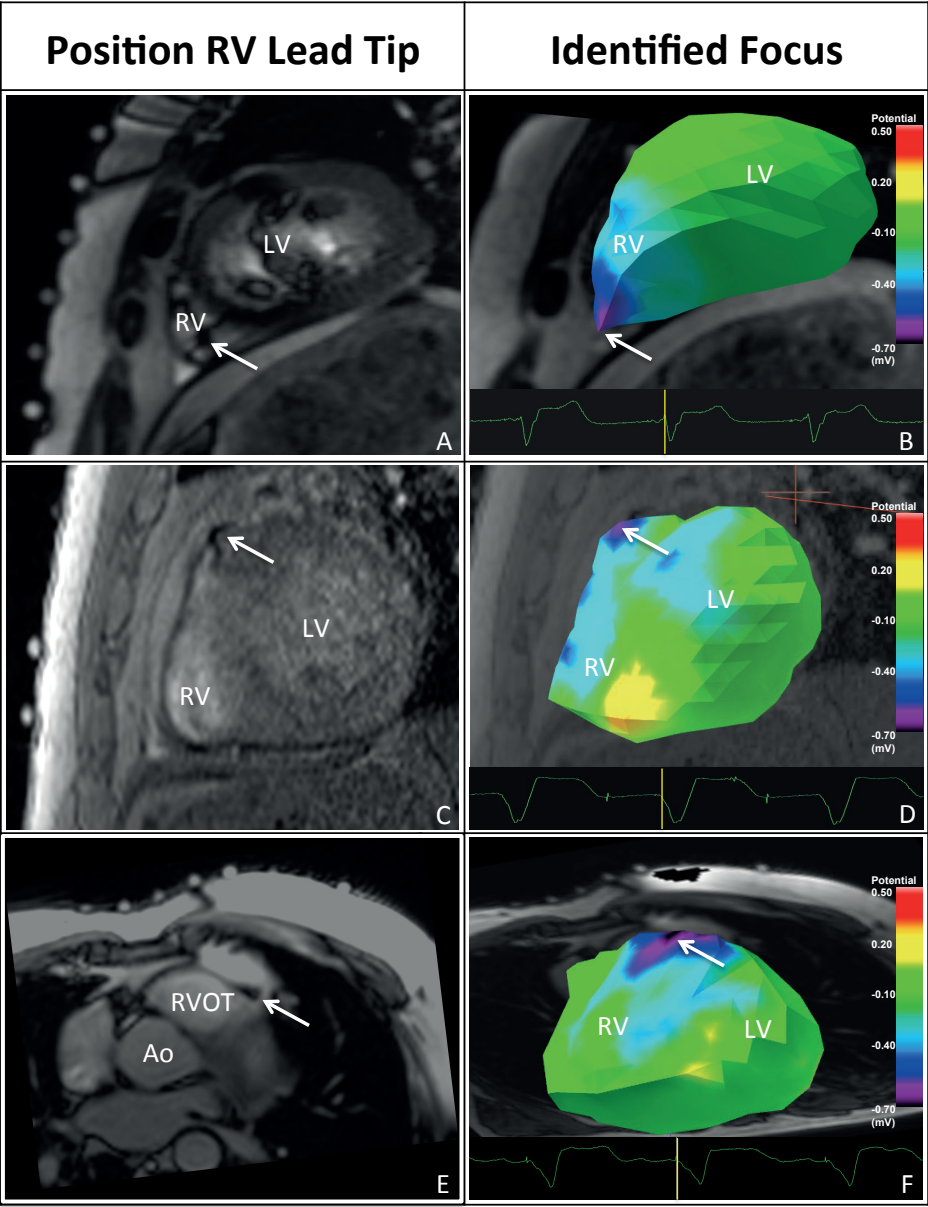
(panels B, D and F) provides typical examples of MRI images used to identify the position of RV lead and the RV lead tip.
